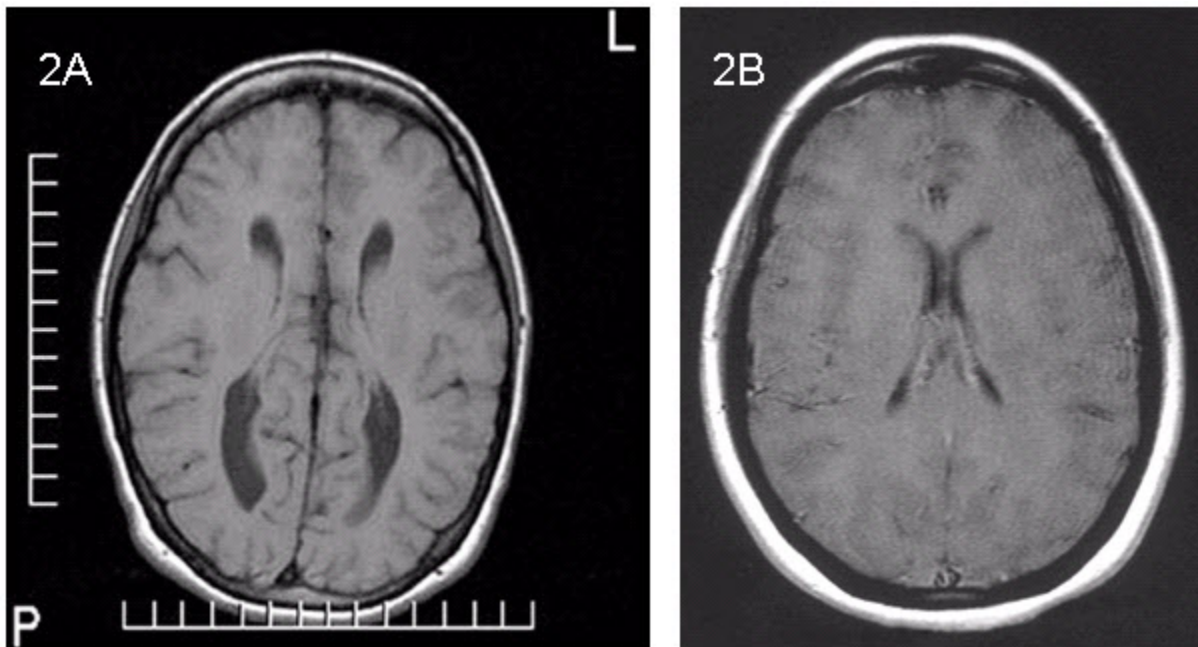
Axial T₁-weighted MRI
